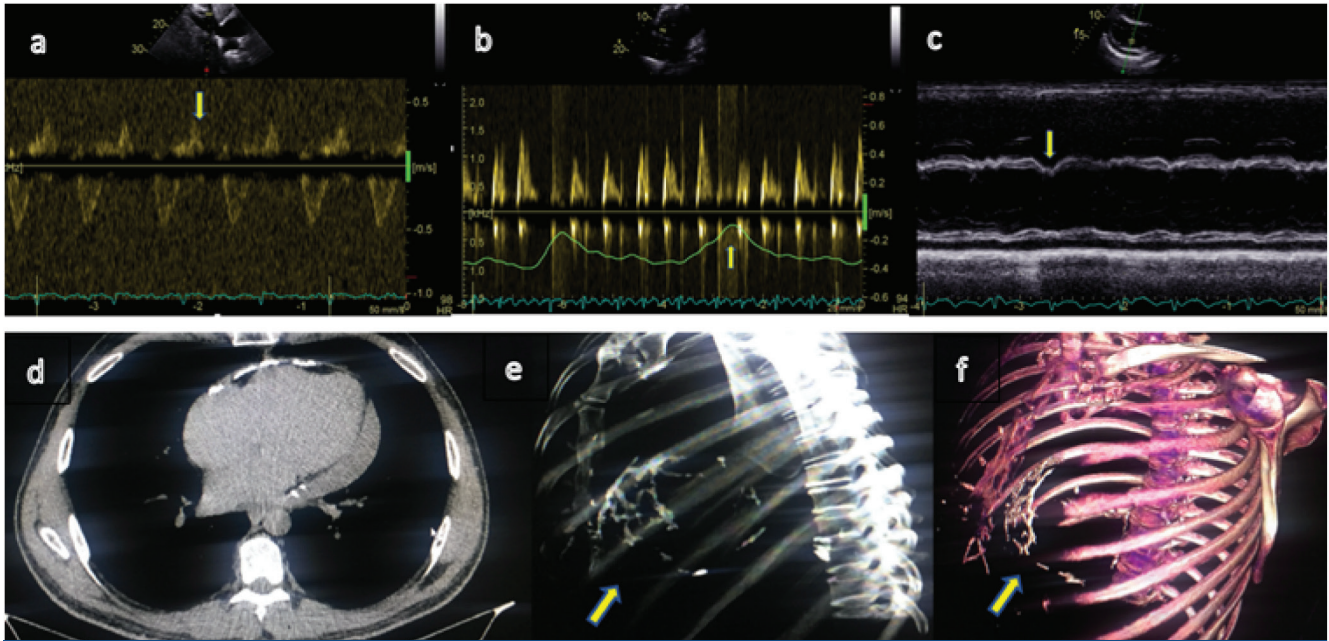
A) Hepatic flow reversal with IVC plethora. B) Hemodynamic information bet seen by echo C) Diastolic septal bounce best seen on M mode as septal notch in early diastole. D, E, F) CT showing pericardial calcification.
